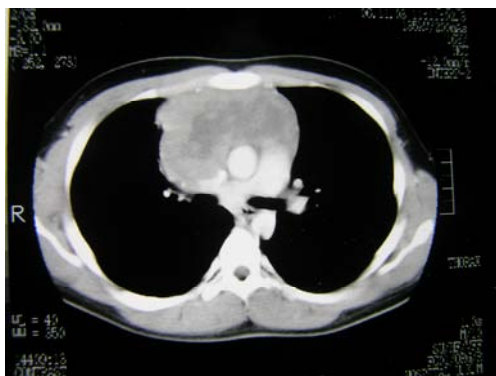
CT of thorax showed an anterior mediastinum mass with a diameter of 6x10x11cm that abutted the great vessels and posteriorly displaced and compressed the SVC.
